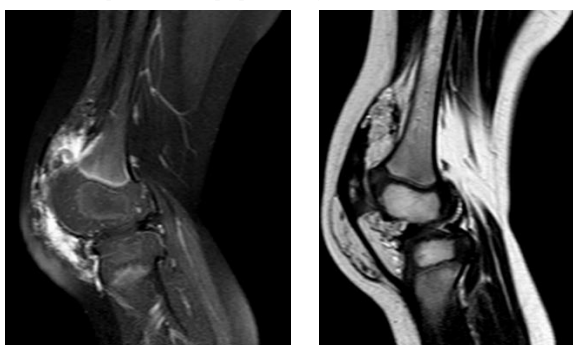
(A) T2 MRI and (B) T1 MRI images of the PVNS. Images delineate the extent of the PVNS anterior to the patella and subcutaneous area.
